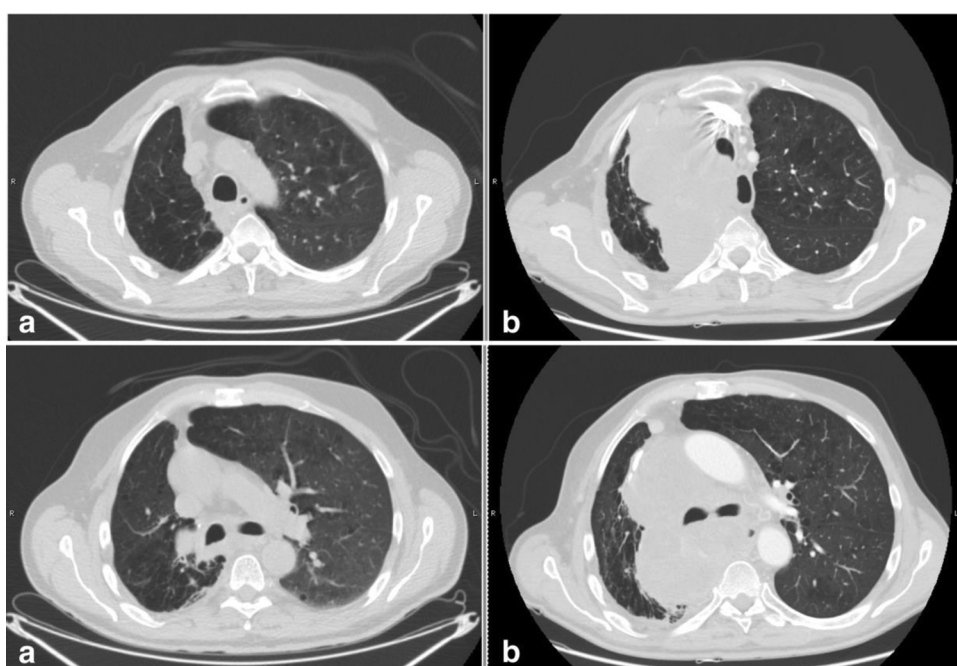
CT scans of HPD from our casuistry. A Caucasian 57-years old man diagnosed with locally-advanced NSCLC treated with neoadjuvant chemotherapy (cisplatin/pemetrexed, four cycles from March to May 2016) and then subjected to right inferior bilobectomy with ilo mediastinal lymphadectomy in July 2016. A PET/CT in October 2017 documented pulmonary and nodal relapse of the disease (a). Molecular analysis showed PD-L1 positivity with Tumor Proportion Score (TPS) 60%, therefore in November 2017 treatment with Pembrolizumab flat dose was started. CT scans of February 2018 (b) revealed a severe thoracic progression of disease, with massive nodal increase with vascular, esophageal and cardiac involvement.
